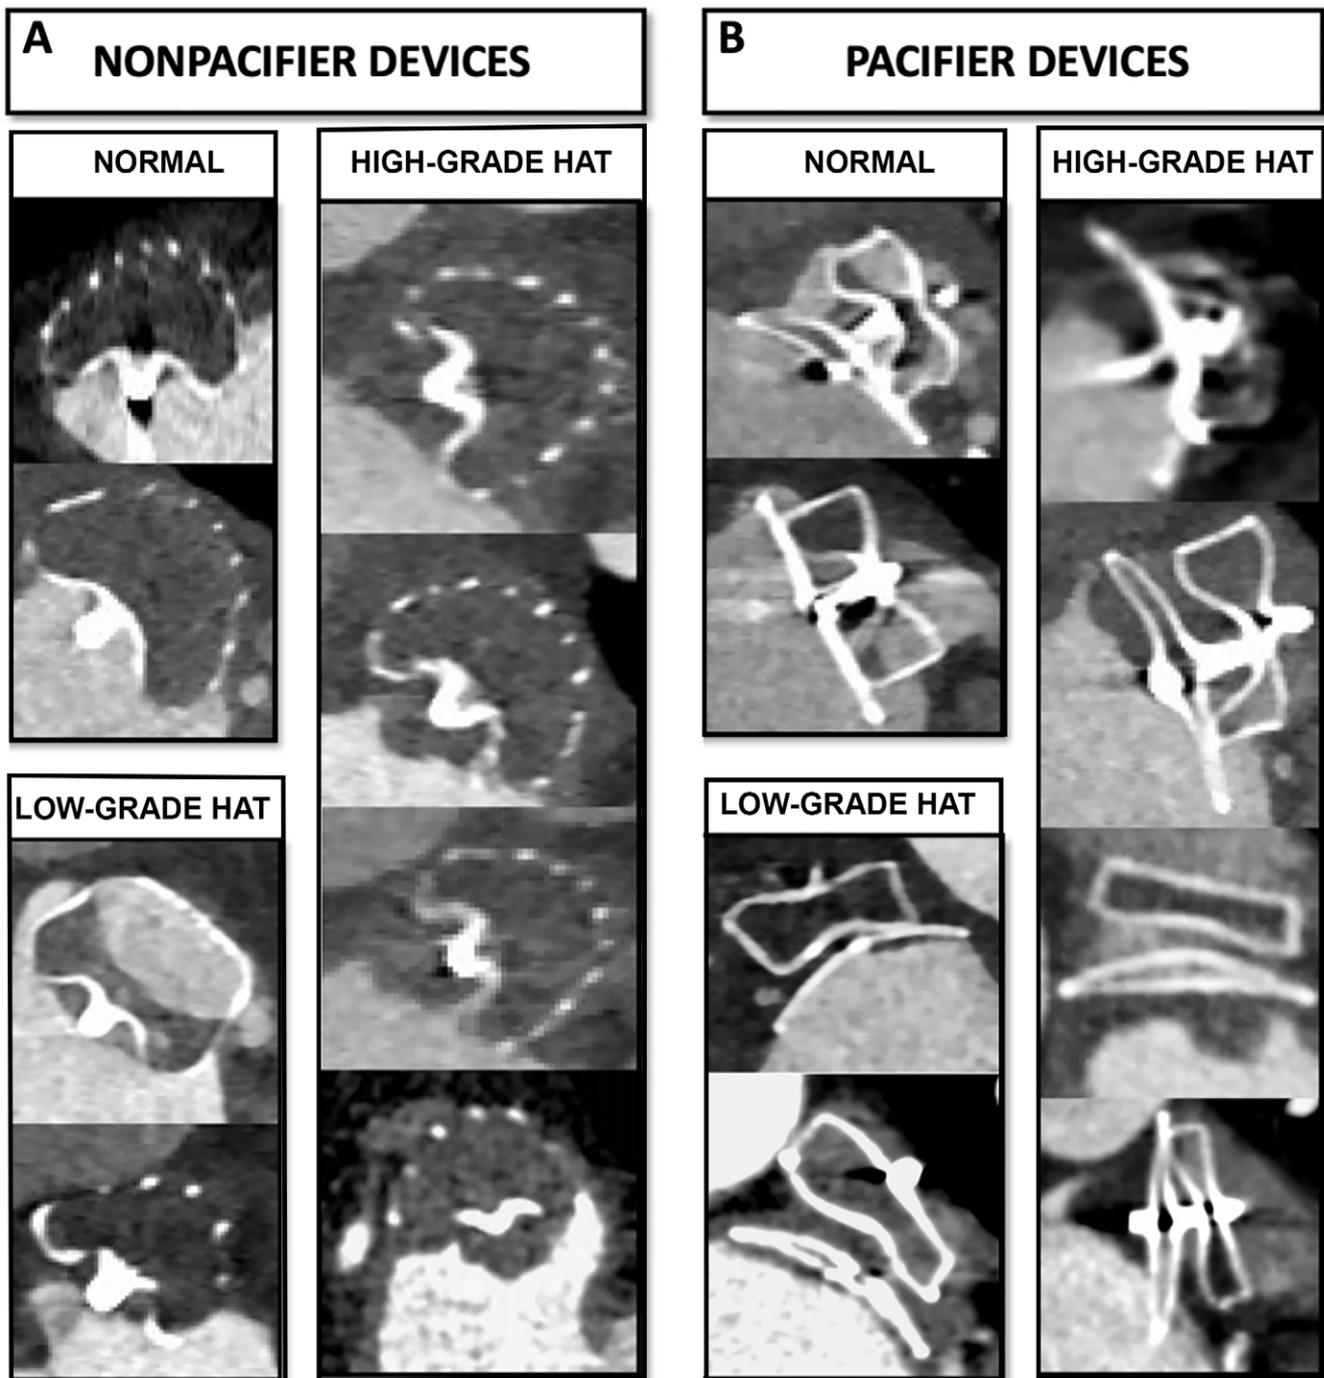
Examples of CT findings after left atrial appendage occlusion (LAAO). Contrast-enhanced CT images acquired in 16 participants (mean age, 77 years \pm 8 (SD); 11 men, five women) after undergoing LAAO are shown. Images are reformatted along the device axis. Normal findings, low-grade hypoattenuated thickening (HAT), and high-grade HAT are shown in participants implanted with (A) nonpacifier and (B) pacifier devices.
